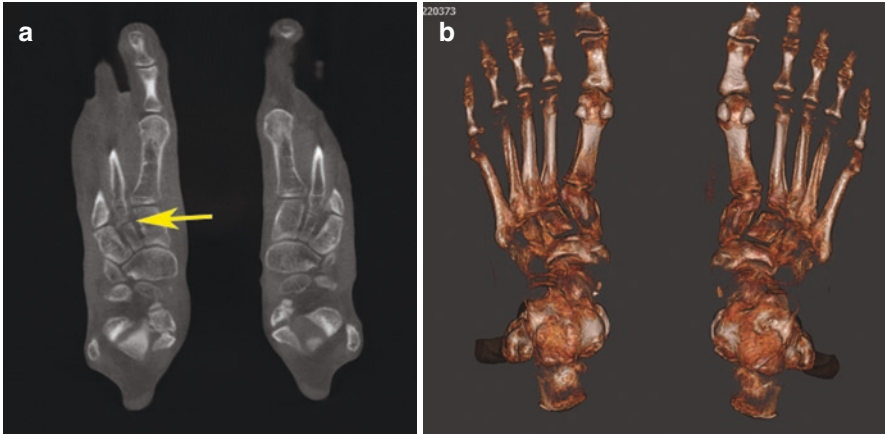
(a, b) Subtle Lisfranc joint instability. (a) shows a lateral shift of the base of the second metatarsal in the second tarsometatarsal joint (arrow) which was not visible on conventional radiographs with weight-bearing or conventional CT without weight-bearing. (b) shows a 3D reformation
